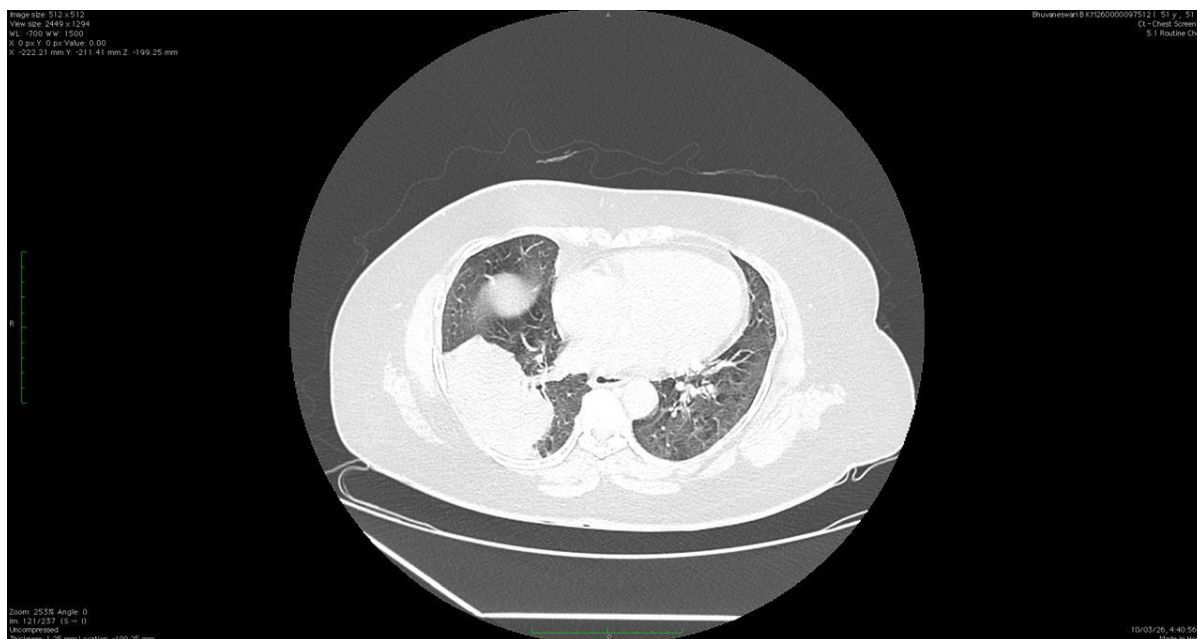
Axial CT image (lung window) showing the right lower pleural-based lesion with adjacent collapse/consolidative changes and pleural effusion.
